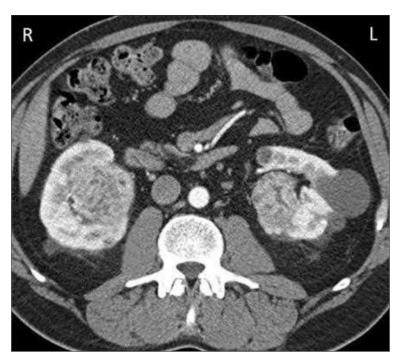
Computed Tomography Scan of Abdomen of a Patient With von Hippel-Lindau Syndrome Showing Bilateral Renal Cell Carcinoma.
